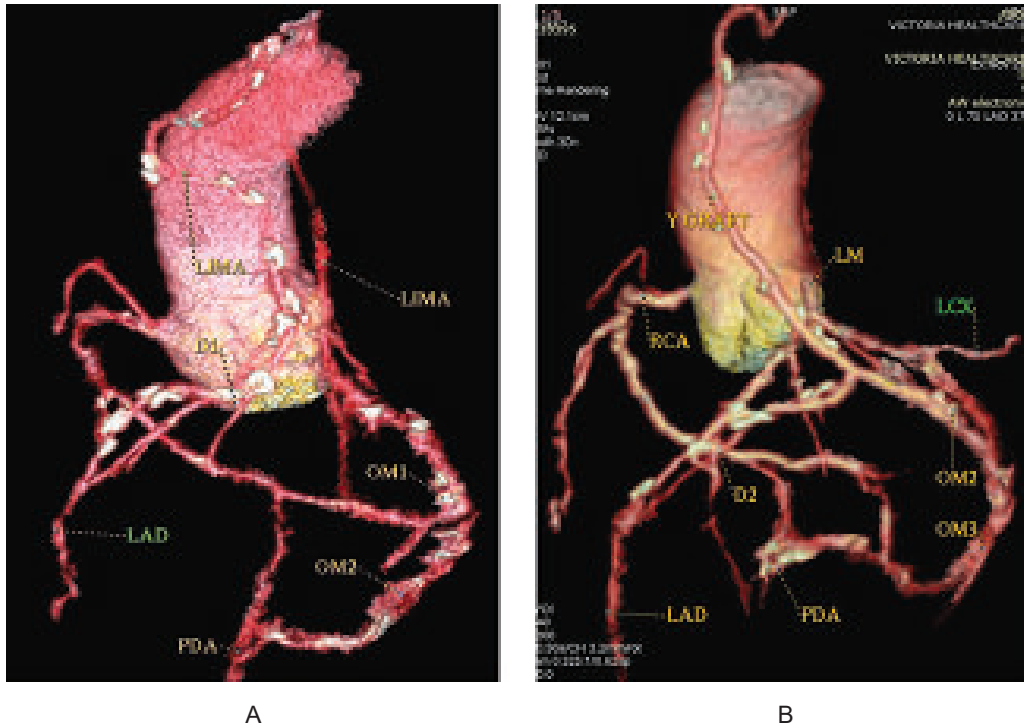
CT angiogram after 1 year of surgery. A. CT angiogram showing patent graft LIMA sequential to D1 & LAD and RIMA Y sequential to OM1, OM2 and PDA.. B. CT angiogram showing patent LIMA sequential to D2 & LAD and RIMA sequential to OM2, OM3 and PDA.
